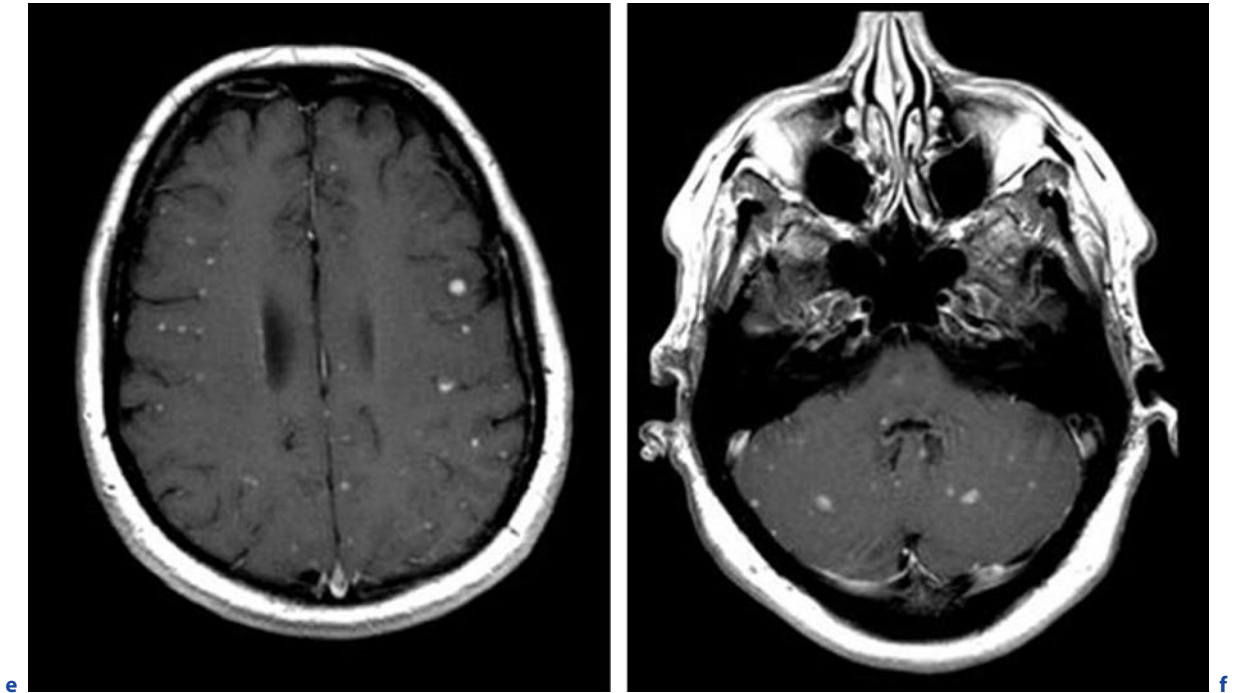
(continued) Cerebral toxoplasmosis in an immunocompetent 49-year-old woman. e-f Axial T1-weighted images, DWI, and FLAIR images (a,c), and strong punctate or
